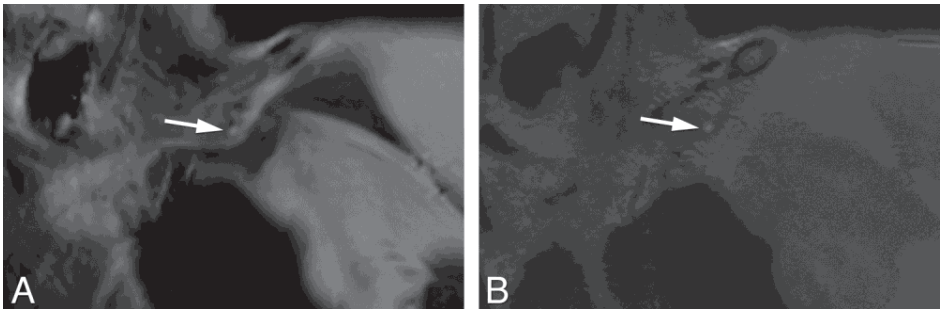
3B– Unenhanced MRI sequences: MRDTI (A) and 3D TSE-SPAIR (B) acquisitions of the upper extremities, coronal view.
